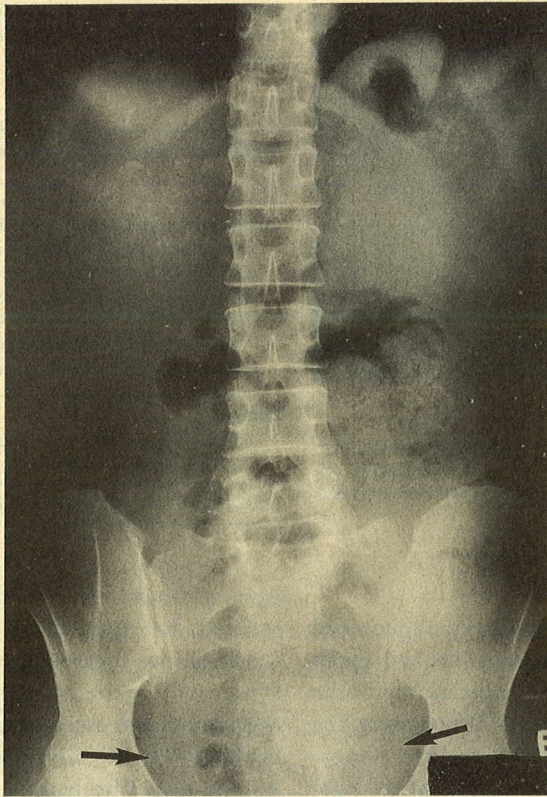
Abdominal radiograph.
